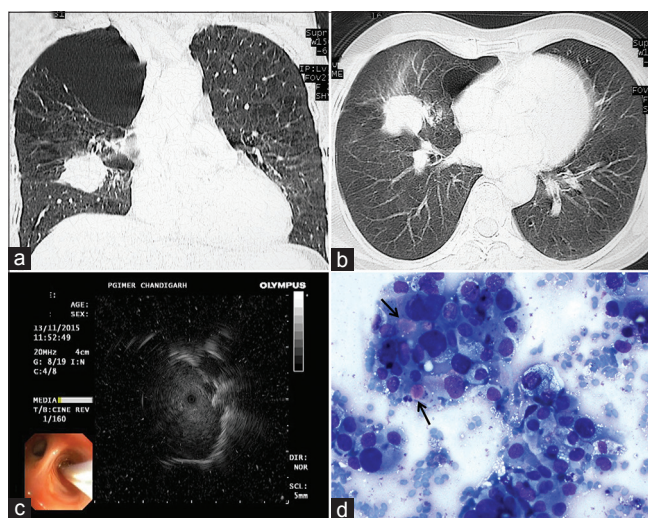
Computed tomography chest showing a spiculated nodule in the middle lobe of the right lung (a, coronal section; b, axial section). The nodule is surrounded by lung parenchyma on all sides and is away from the hilum. Radial ultrasound image (c) showing the lung nodule along with the placement of the radial probe in the lateral segment of the right middle lobe (inset). (d) A cluster of tumor cells showing moderate nuclear pleomorphism, round nuclei, coarse chromatin, occasional prominent nucleoli and moderate amount of vacuolated cytoplasm with intracytoplasmic mucin (arrows, MGG, ×40)
